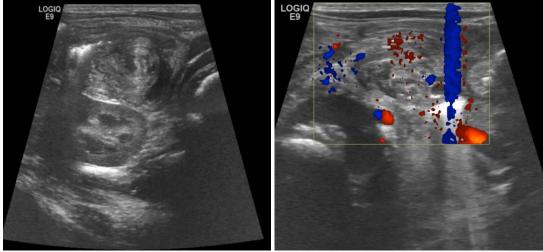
(a) B-mode ultrasound showing a pseudo-mass with a whirlpool appearance in the epigastric region.
